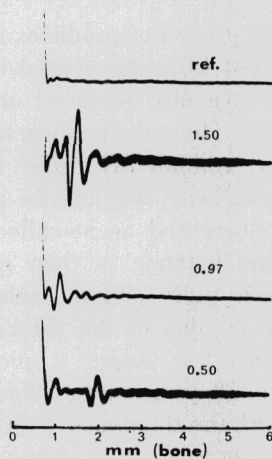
Sonograms from bone slices.
